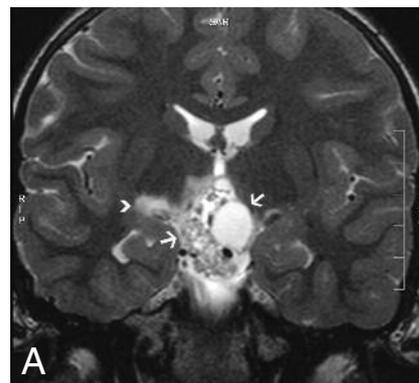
Patient 2. A. Coronal T2-weighted image (TR: 6110 ms, TE: 91). Notice the heterogeneous mixed cystic and solid suprasellar mass (arrows). There is edema of the right optic tract (arrowhead). B. Axial T2-weighted image (TR: 7240 ms, TE: 122 ms). Notice the suprasellar mass (arrow). There is edema of both optic tracts (arrowhead).
